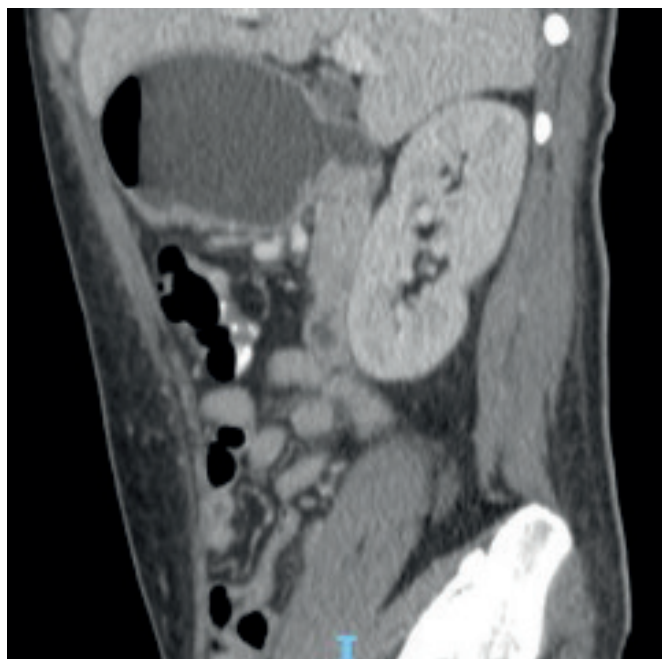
Abdominal CT scan in the sagittal plane shows a concentric thickening in the duodenum causing mechanical obstruction as a cause of GOO symptoms.
